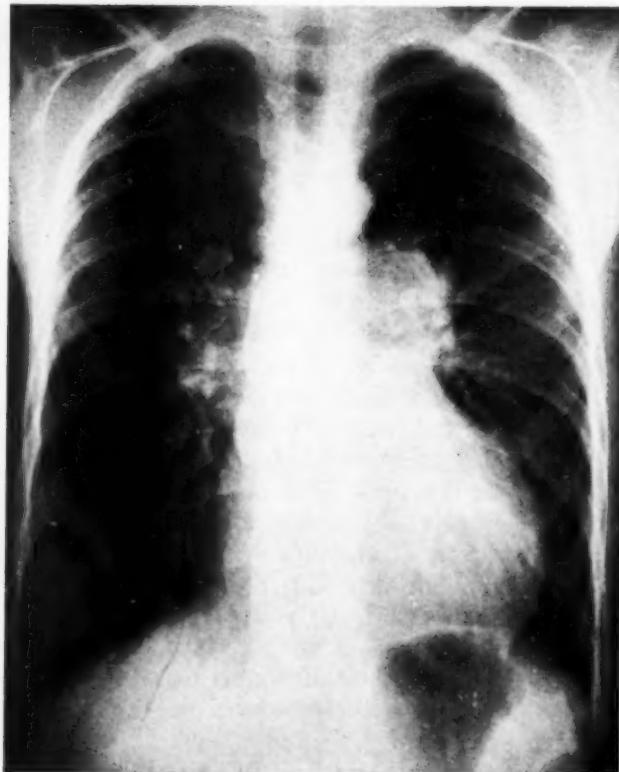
Posteroanterior chest radiograph, showing large pulmonary arteries, moderately enlarged heart, and translucent right lower lobe.
